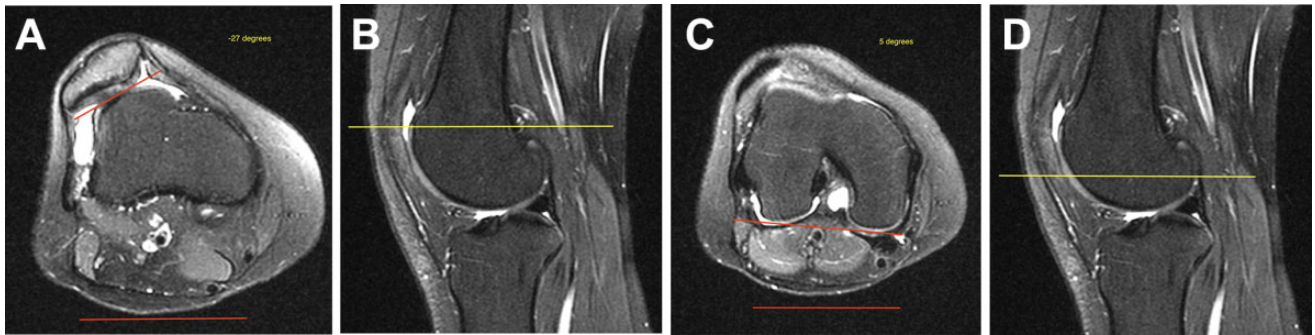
Measuring lateral trochlear inclination (LTI) in a patient with a convex/spurred trochlea. (A) A best-fit line between the cartilaginous surface of the lateral trochlea and the apex of the convexity was used to form an angle between the proximal trochlea and a horizontal line represented by the red lines. In this example, the single-image LTI measured -27° and was assigned a negative value because the apex of the angle was toward the lateral aspect of the distal femur. (B) Cross-referenced sagittal magnetic resonance imaging (MRI) scan confirming that the axial image in part A was the most proximal aspect of the trochlea represented by the yellow line. One can note the marked proximal extent of trochlear cartilage relative to the femoral condyles in this patient with a highly dysplastic trochlea. (C) Axial MRI scan taken where the posterior femoral condyles were clearly visible. An angle was measured between the condyles and a horizontal line represented by the red lines. In this example, the angle of the condyles had an apex toward the medial aspect of the femur and was thus assigned a positive value of 5° . Thus, the 2-image LTI measurement for this patient was $-27^\circ - 5^\circ = -32^\circ$. Had the femoral condyles been externally rotated 5° (the apex of the angle pointed toward the lateral femur), the angle would have been assigned a negative value, and the 2-image LTI calculation would have been $-27^\circ - (-5^\circ) = -22^\circ$. (D) Cross-referenced sagittal MRI scan showing the level, relative to the proximal trochlea, at which the angle of the posterior femoral condyles was measured represented by the yellow line. In this example, it was 15 mm (5 MRI cuts) distal to the proximal trochlea.
